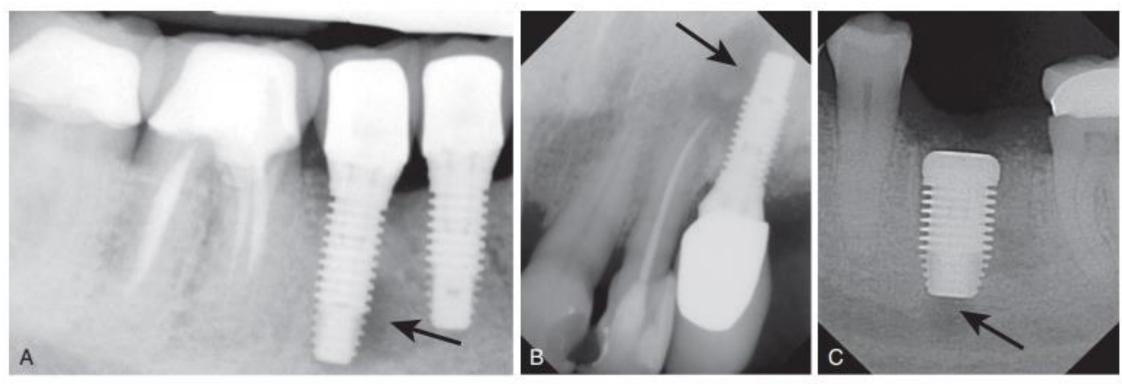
Retrograde periapical lesion. (A–B) Apical pathology on integrated dental implants. (C) Apical radiolucency from osteotomy preparation exceeding implant length.
